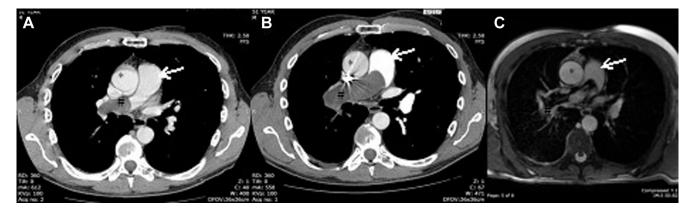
Panel (A) CTPA at initial presentation showing filling defect of the pulmonary artery. Panel (B) CTPA four months later showing increased filling defect of pulmonary arteries. Panel (C) MRI with gadolinium contrast displaying delayed enhancement. * Ascending aorta. Arrow: Main pulmonary artery. # Pulmonary artery sarcoma.
